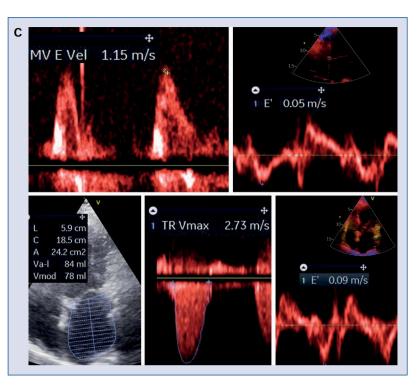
(cont.). C. A 75-year-old woman with atrial fibrillation. Resting echocardiography revealed EF of 57%, concentric LVH (LVMI 111 g/m², RWT 0.58), and e' septal and lateral of 5 and 9 cm/s, respectively (reduced as per ASE/ /EACVI algorithm, but within the norm range for age as per HFA-PEFF score), with E/e' of 16.4, LAVI of 42 mL/m², and moderate TR with TRV of 2.73 m/s. NT-proBNP was 849 pg/mL. According to the ASE/EACVI algorithm, the patient has diastolic dysfunction. This is consistent with the result of the HFA-PEFF score (six points, diagnosis of HFpEF); BSA — body surface area; CCS — chronic coronary syndrome; EF — ejection fraction; HFpEF — heart failure with preserved ejection fraction; LA — left atrium; LAVI — left atrial volume index; LV — left ventricle; LVH — left ventricular hypertrophy; LVMI — left ventricular mass index; NT-proBNP — N-terminal pro-B-type natriuretic peptide; RWT — relative wall thickness; TRV — tricuspid regurgitation velocity.
